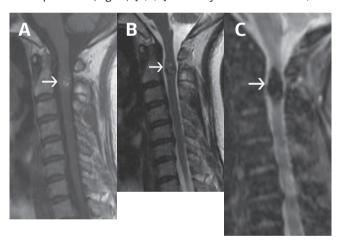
Cavernous malformation. A 61-year-old female with an incidentally revealed spinal cord cavernous malformation (CM). Sagittal T1- weighted (A) and T2- weighted (B) spinal MR images show a focal area of hyperintensity with a hypointense rim on the right side of the cervical cord (arrow). (C) The lesion "blooming" artifact on a sagittal gradient echo image (arrow).
